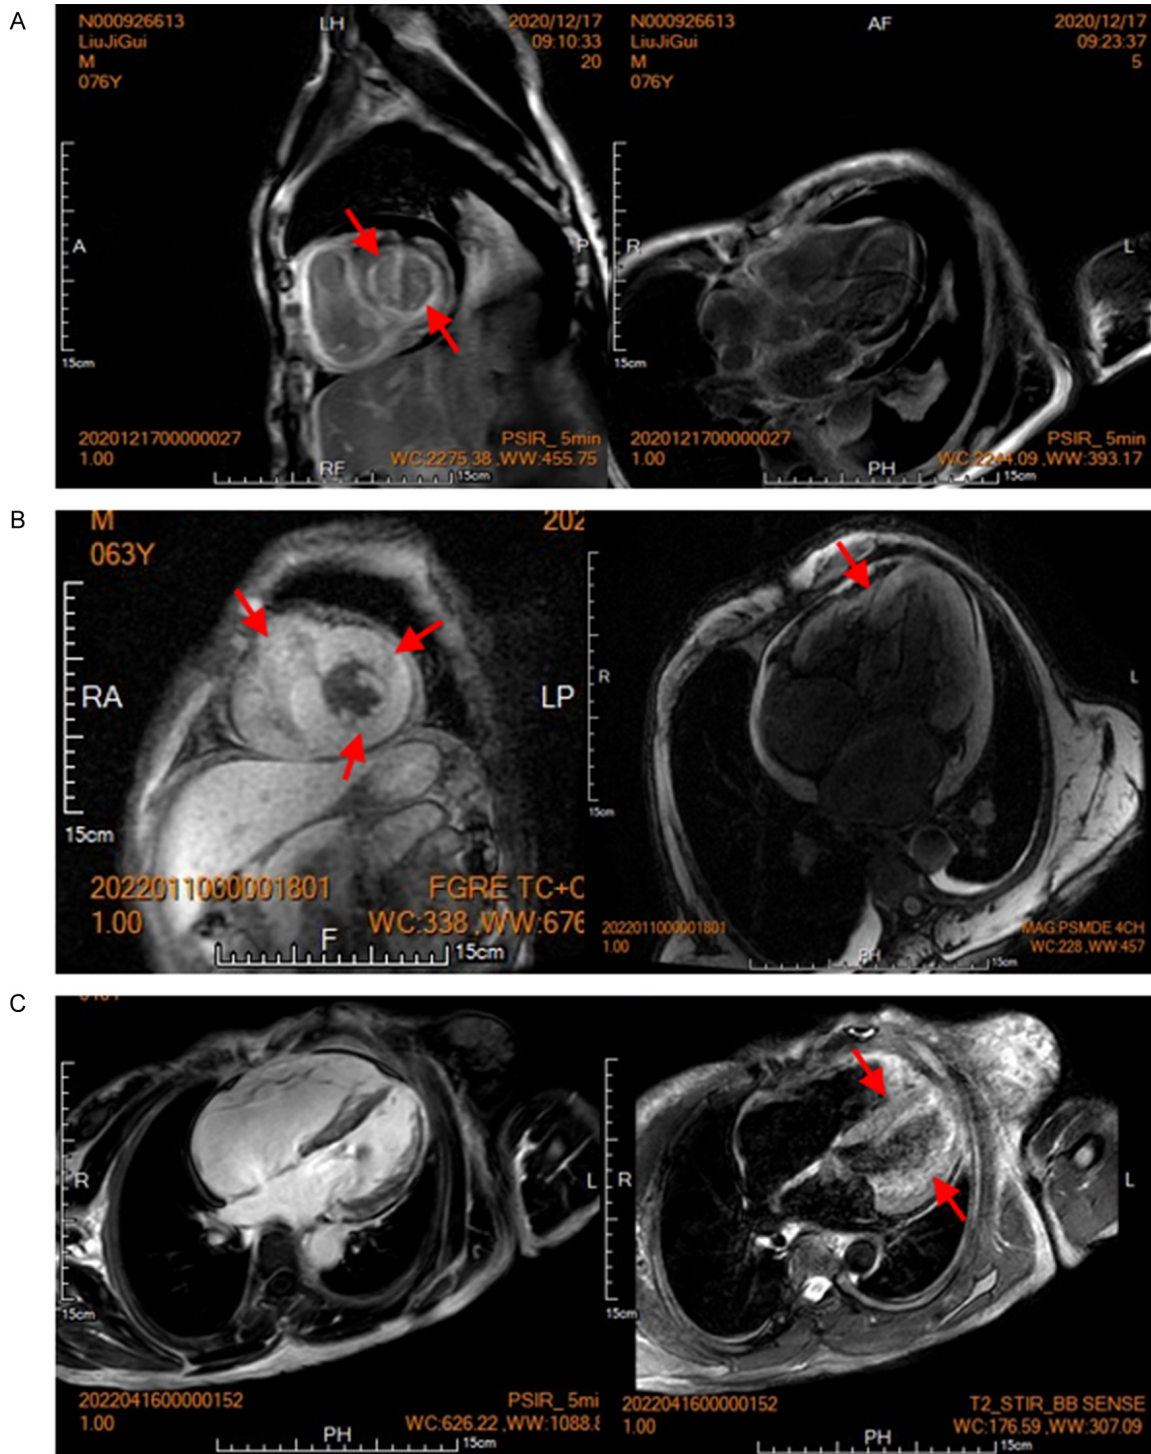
Typical representative legend of cardiac MRI results in CA patients. A: 1. The ventricular septum and the posterior wall of the left ventricle were thickened, and the left and right ventricles and atria were diffused to delay subendocardial enhancement; 2. Enlarged heart, reduced left ventricular systolic and diastolic function, pericardial effusion; 3. Mild regurgitation of mitral and tricuspid valves. B: 1. Left atrium enlargement with atrial muscle thickening, left ventricular wall symmetry thickening; 2. Slight regurgitation of mitral and tricuspid valves. C: 1. The heart is enlarged (especially in the right heart) and the left ventricular systolic and diastolic function is weakened, and the left ventricular wall is delayed and abnormally strengthened; 2. Small amount of pericardial effusion, tricuspid regurgitation. Note: The red arrow represents the site of amyloidosis in cardiac organ.
